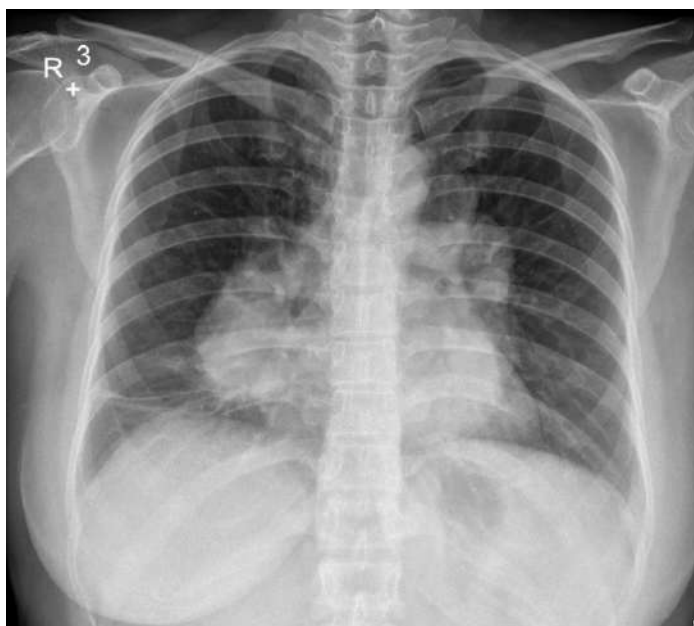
Results of the PA chest X-ray: A lobulated opacity forming an obtuse angle with the mediastinum is visible, projecting at the level of the right paravertebral spaces of T7–T10
